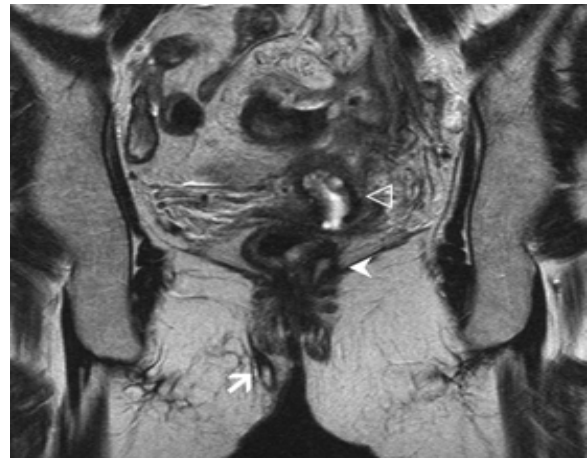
Preoperative coronal MR image of the perianal region It revealed the fistula track (arrow) filled with pus within the perianal fat tissue on the right side and on the left side, its supra-levator component (arrowhead) is near the inflamed sigmoid colon (hollow triangle)
